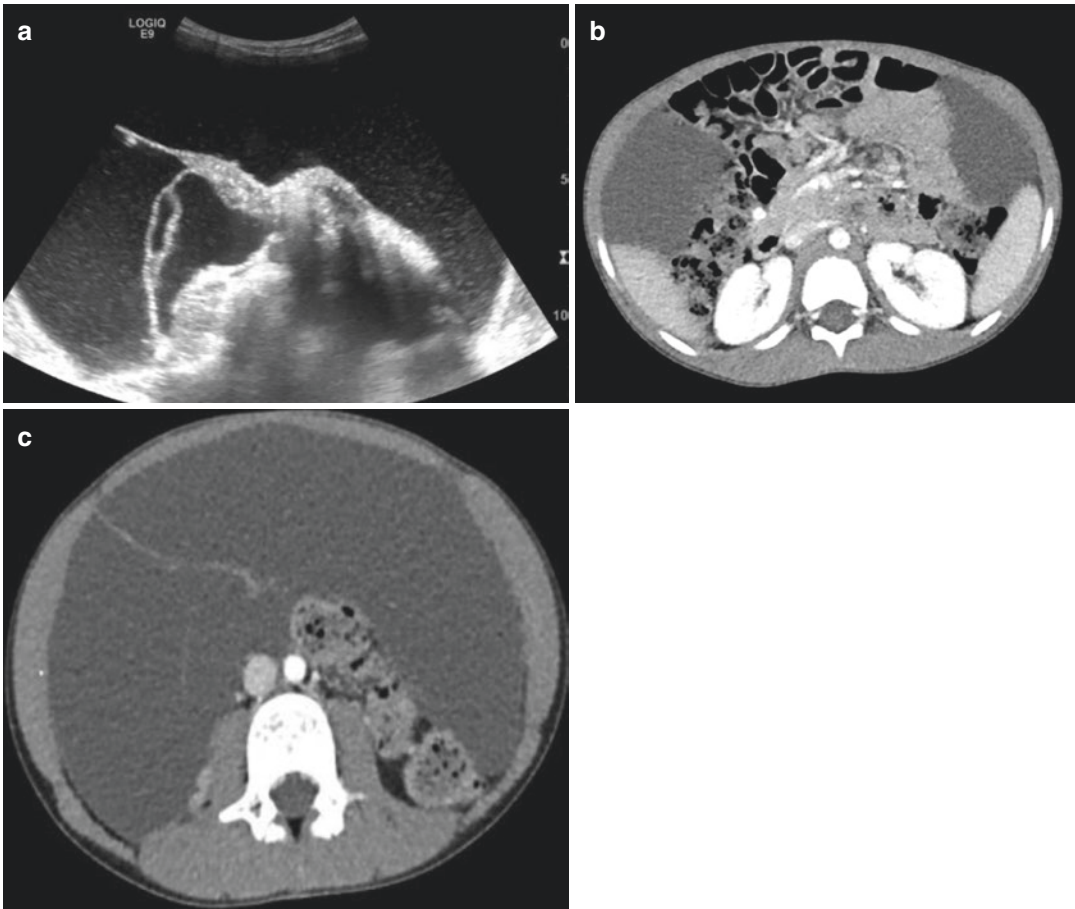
Giant lymphatic malformation (lymphangioma). (a) US—A large part of the abdomen is occupied by a cystic mass with some septations. (b) CE-CT of the upper abdomen—The bowel loops are displaced towards
